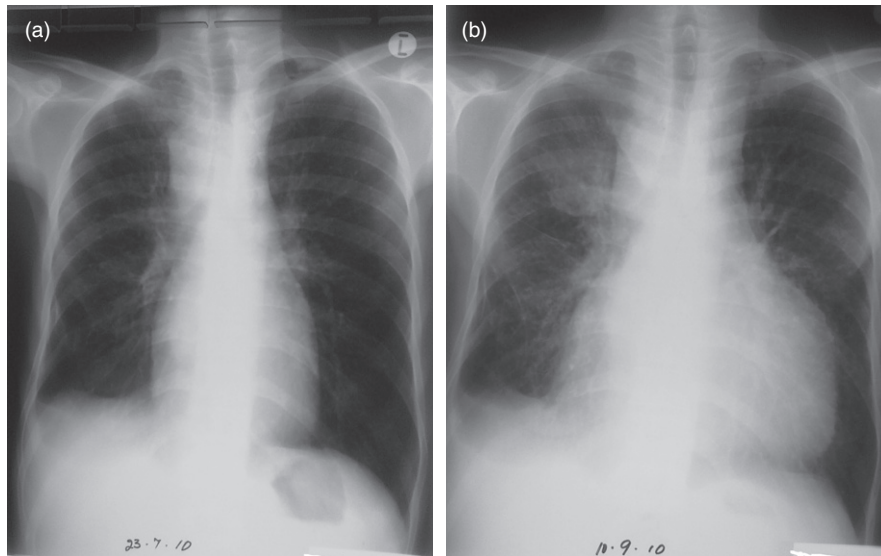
This human immunodeficiency virus (HIV)-infected man had a CD4 count of 113 cells/ μ L and was diagnosed with pulmonary and nodal tuberculosis (TB). He started highly active antiretroviral therapy (HAART) 4 weeks after TB treatment. Three weeks after starting HAART he had recurrence of TB symptoms attributed to TB-immune reconstitution inflammatory syndrome. His chest X-ray taken at this time (b) when compared with his pre-antiretroviral therapy one (a) showed enlargement of mediastinal lymphadenopathy, worsening pulmonary infiltrate and massive enlargement of the cardiac shadow due to a pericardial effusion. He required urgent pericardiocentesis (1.5 L drained) and was treated with prednisone for 7 weeks with resolution of symptoms and no recurrence of the effusion.
